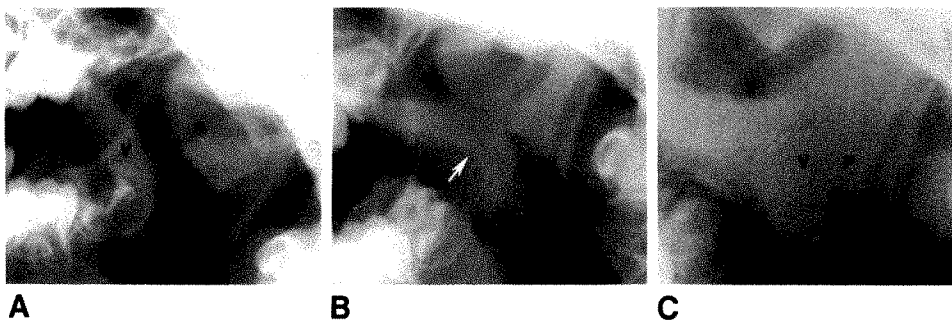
Radiographs of normal palate, lateral projection.
